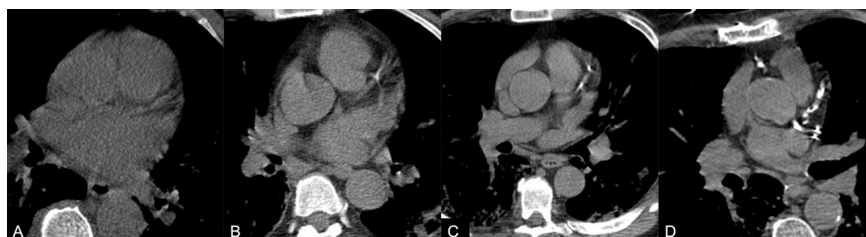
Axial non-gated CT of four different patients exemplifying the CAC score. A – no calcifications. B – mild calcifications. C – moderate calcifications. D – severe calcifications.
